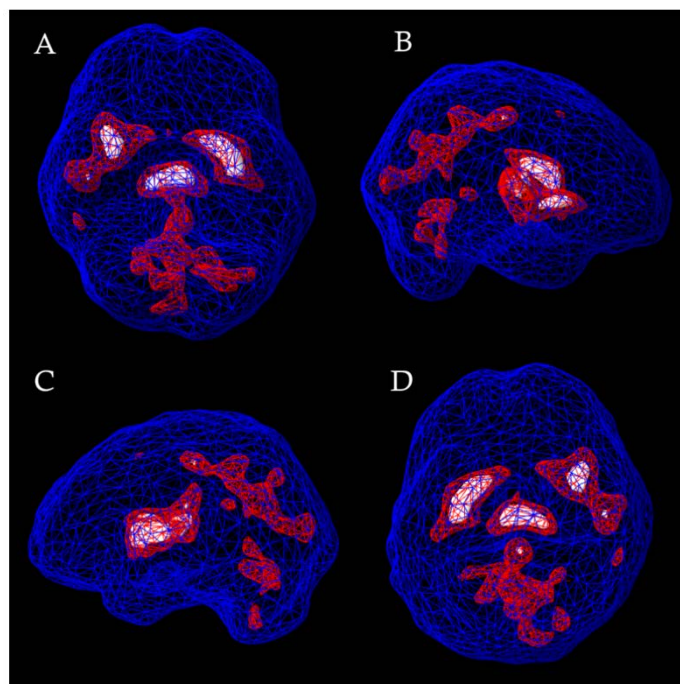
Subcortical brain perfusion SPECT images. Resting subcortical images demonstrating relative regional tracer distribution. (A) Inferior (underside) view. (B) Right lateral view. (C) Left lateral view. (D) Superior (top-down) view. Relatively increased tracer activity was described in the anterior cingulate, left greater than right basal ganglia and thalami, right insular cortex, right temporal lobe, and mid cingulate. The color-rendered findings represent qualitative differences in relative tracer intensity and do not provide absolute cerebral blood flow measurements. SPECT, single-photon emission computed tomography
